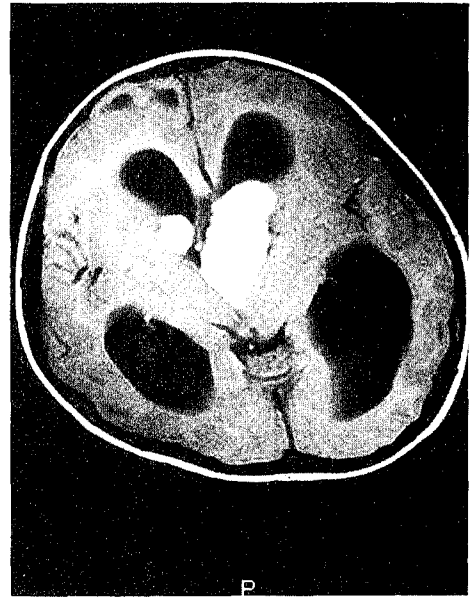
MRI of brain also showing the same findings. 1.0 Tesla, VISTA 2055 HP, TR/TE=600/20 msec. Intravenous contrast enhancement with Gd-DTPA.
